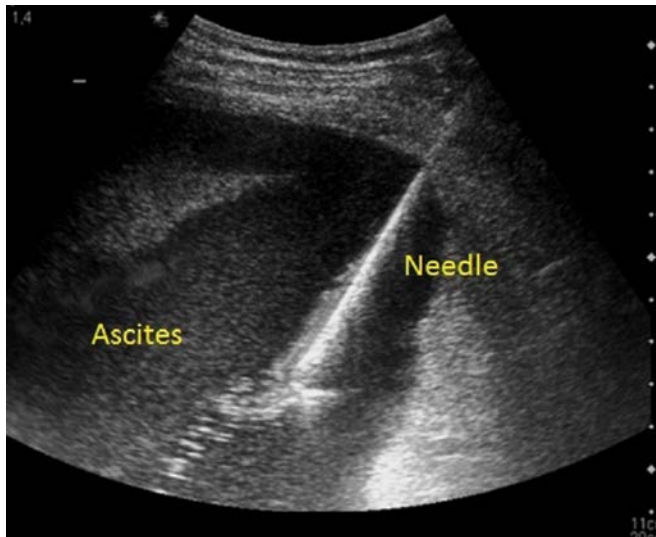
Transabdominal ultrasound-guided paracentesis for ascites drainage in a woman with advanced-stage ovarian cancer.
